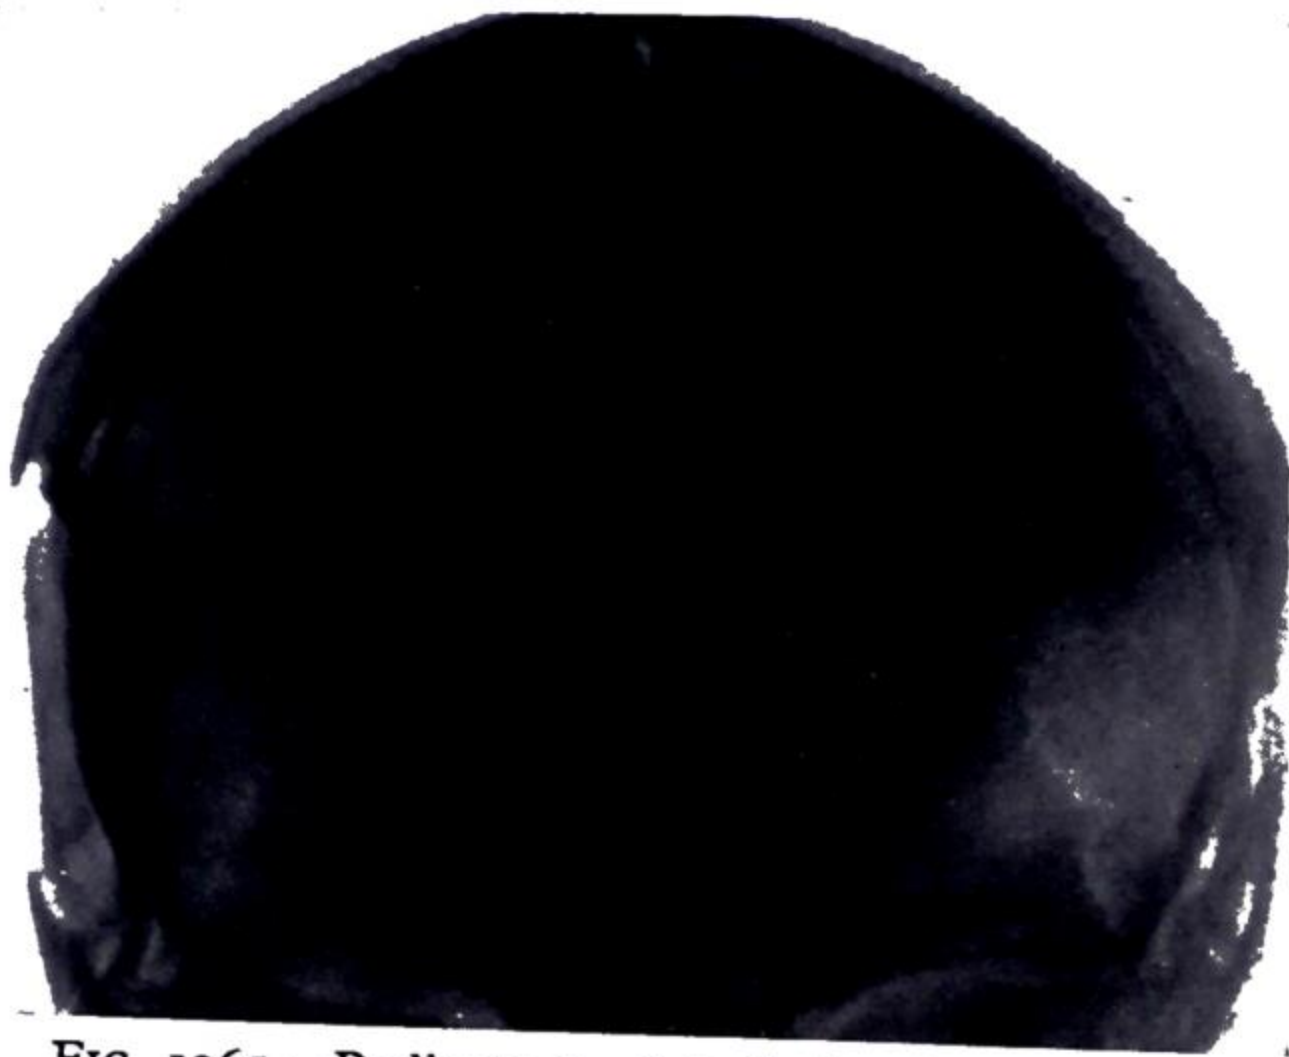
Radiograph of skull showing inward displacement of the right temporal plate. This caused urgent symptoms of cerebral compression in the early stages after injury.
